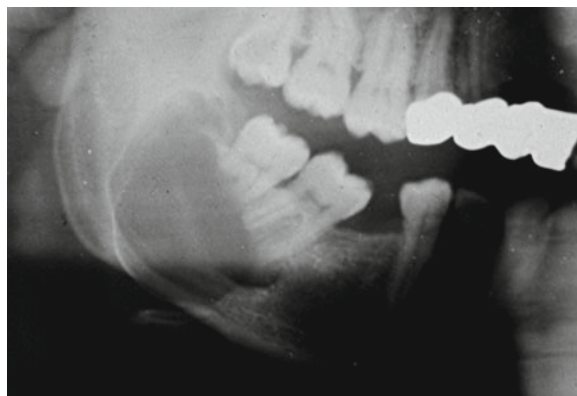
Ortho-panoramic X-ray of ameloblastoma of the right mandible. Unilocular radiolucency resembling cysts with scalloped borders
